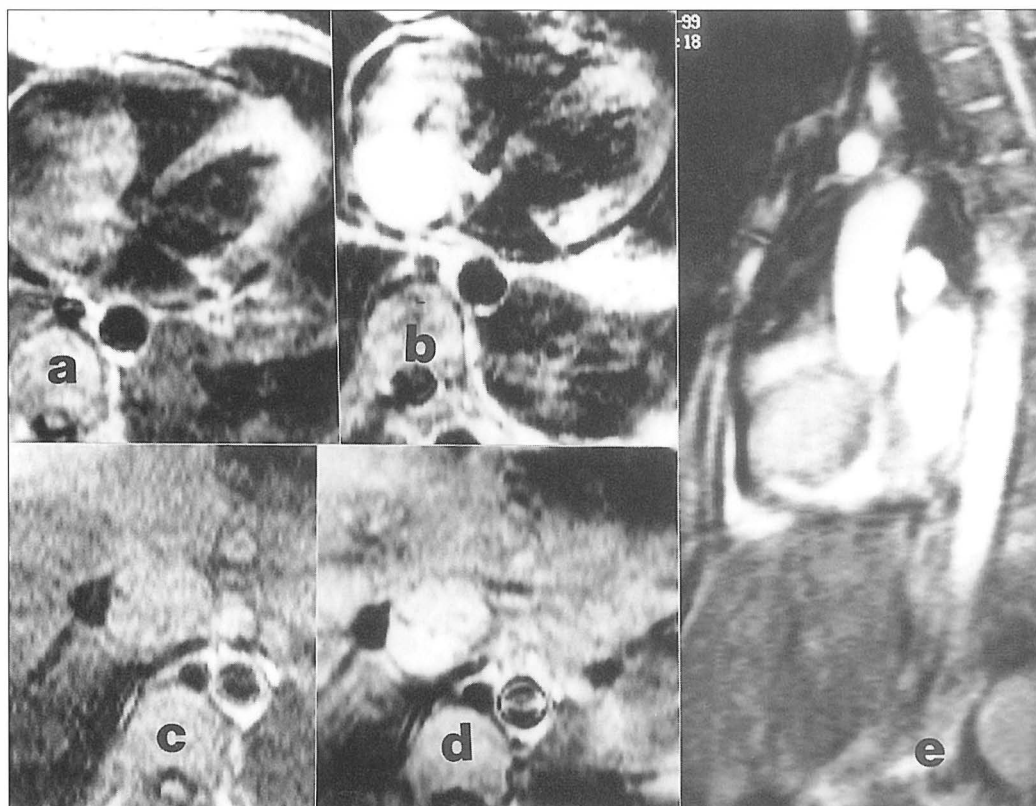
Leiomyosarcoma of the inferior vena cava extending to the right atrium. T1-weighted axial SE images before (a and c) and after (b and d) the administration of Gd-DTPA. The tumor almost completely fills the right atrium, bulges to the right ventricle and blocks VCI. Extensive enhancement after contrast administration (b and d); it is clear that the mass in VCI is not a thrombus but a tumor. e - GE in sagittal plane. A mass of intermediate signal intensity surrounded by the bright intracavitary blood. We performed transjugular biopsy to determine the tumor nature.
